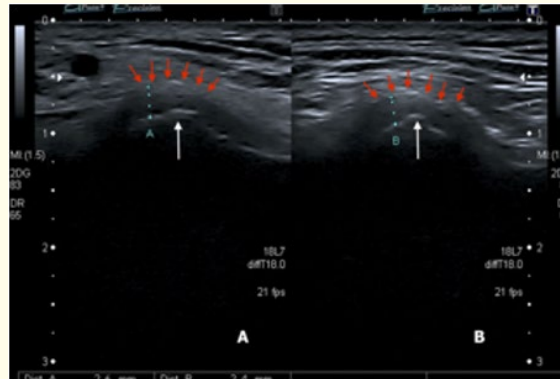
Protocol for ultrasound synovitis is described as thicker synovia, joint effusion, and active synovial inflammation [16].
